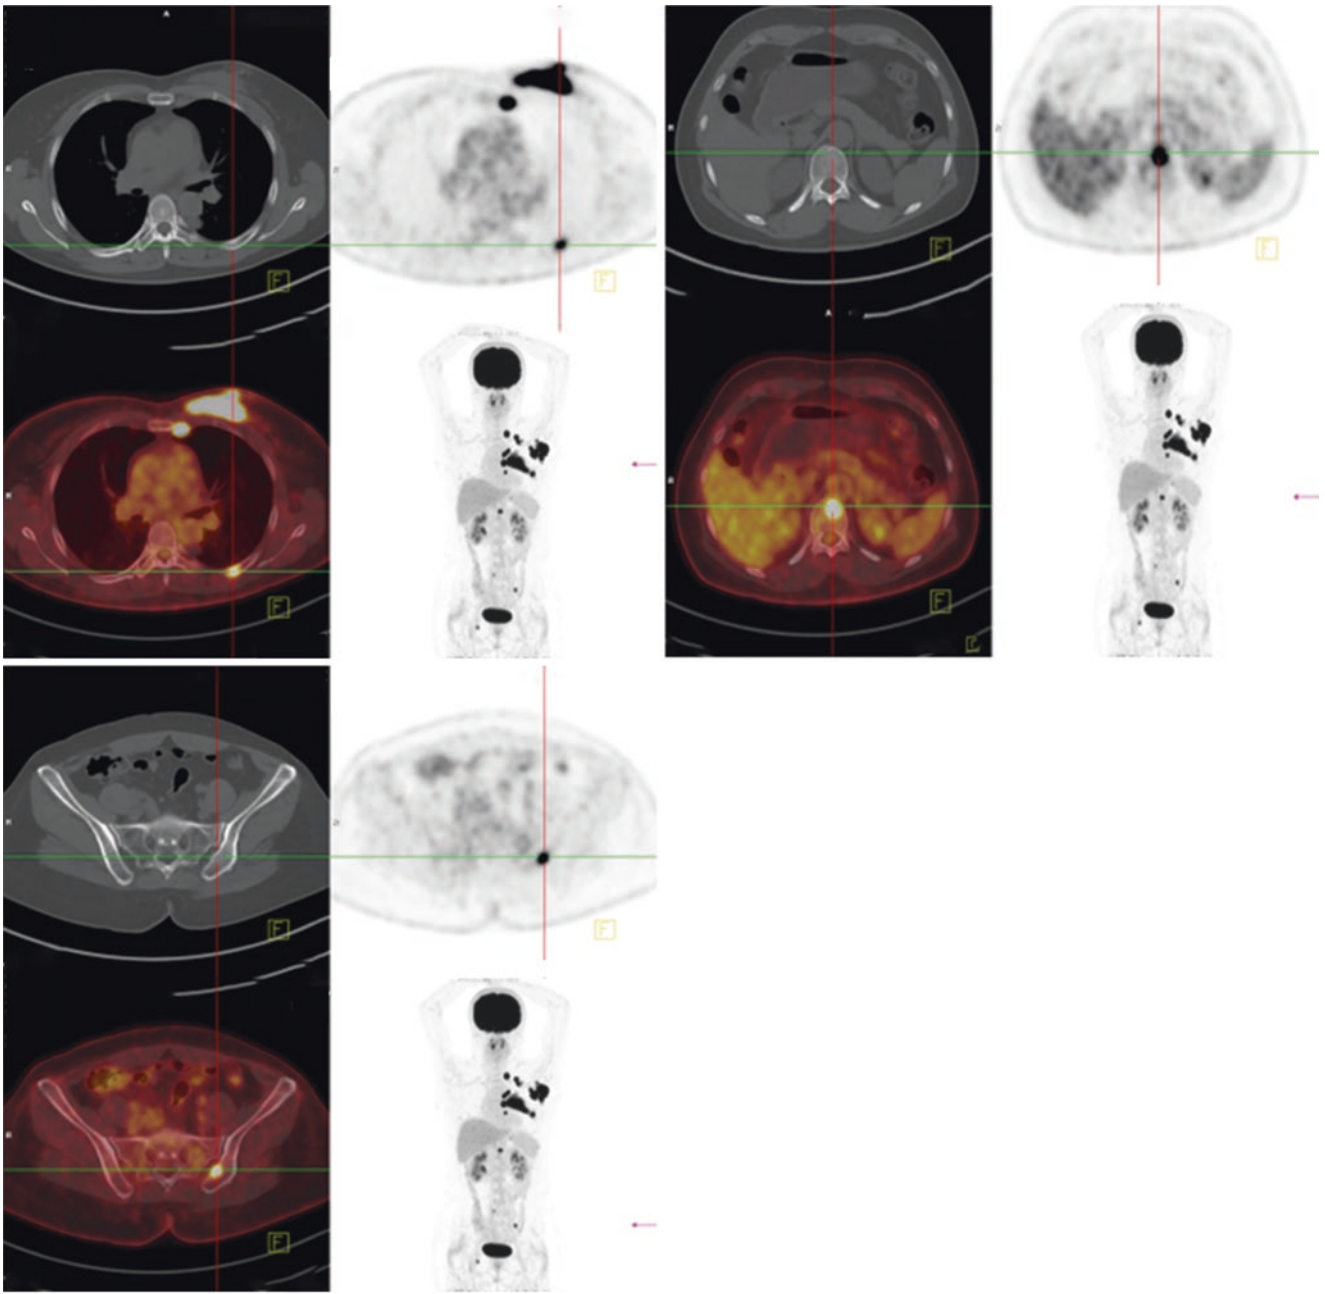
PET/CT—multiple increasing metabolism of bone
